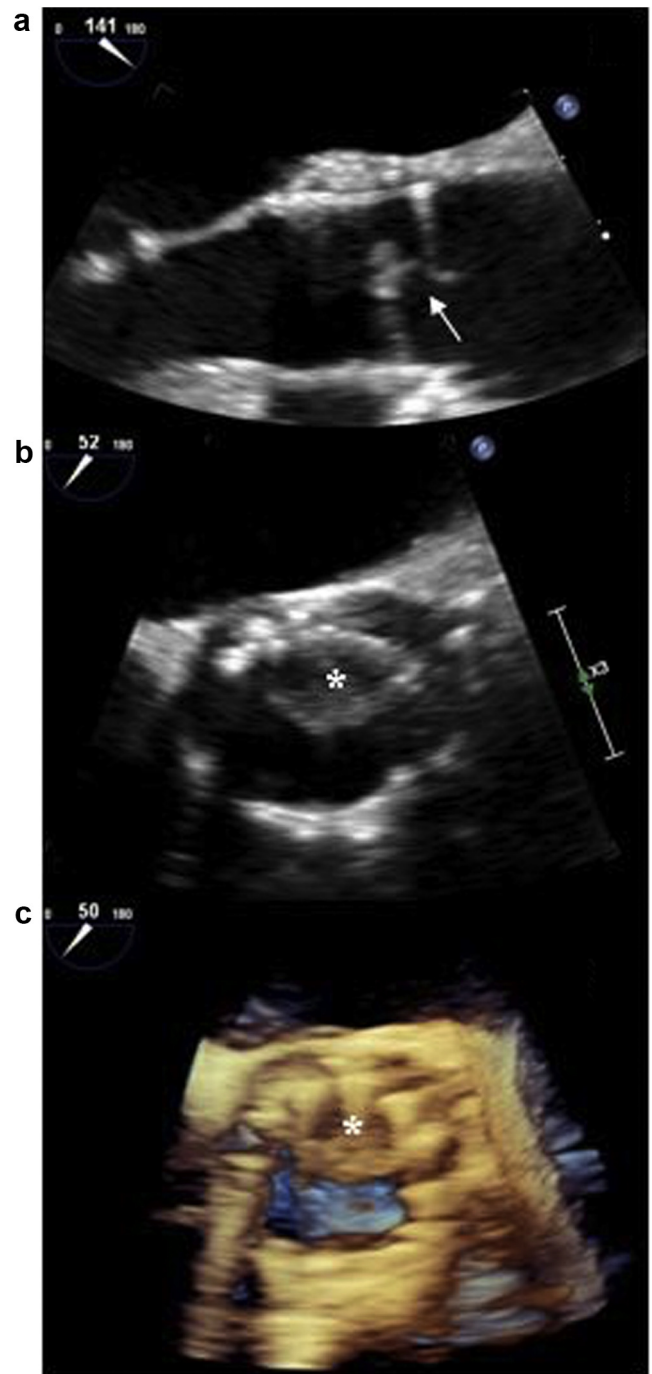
Transesophageal echocardiography mid-esophageal long-axis view (a), demonstrating a prominent vegetation attached to the prosthetic leaflets (arrow); Transesophageal echocardiography mid-esophageal short-axis view (b), demonstrating a prominent vegetation arising from the prosthesis posteriorly (*); 3-dimensional transesophageal echocardiography (c) provides further characterization of the prominent vegetation (*).
